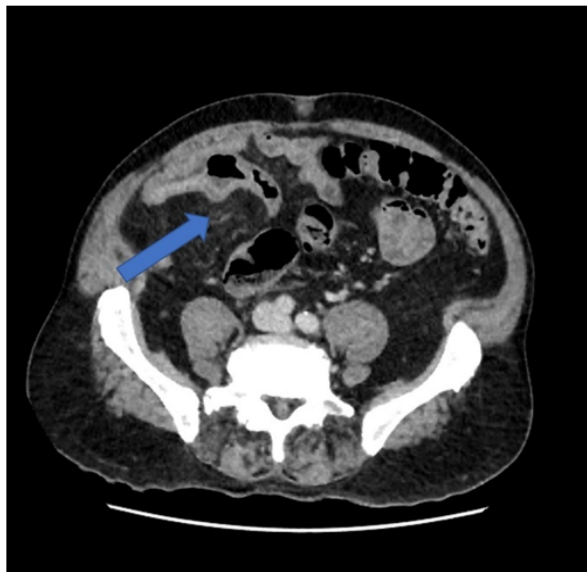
Axial film of the CT scan showing the blind ending diverticulum extending from the distal aspect of the ileum (arrow).
